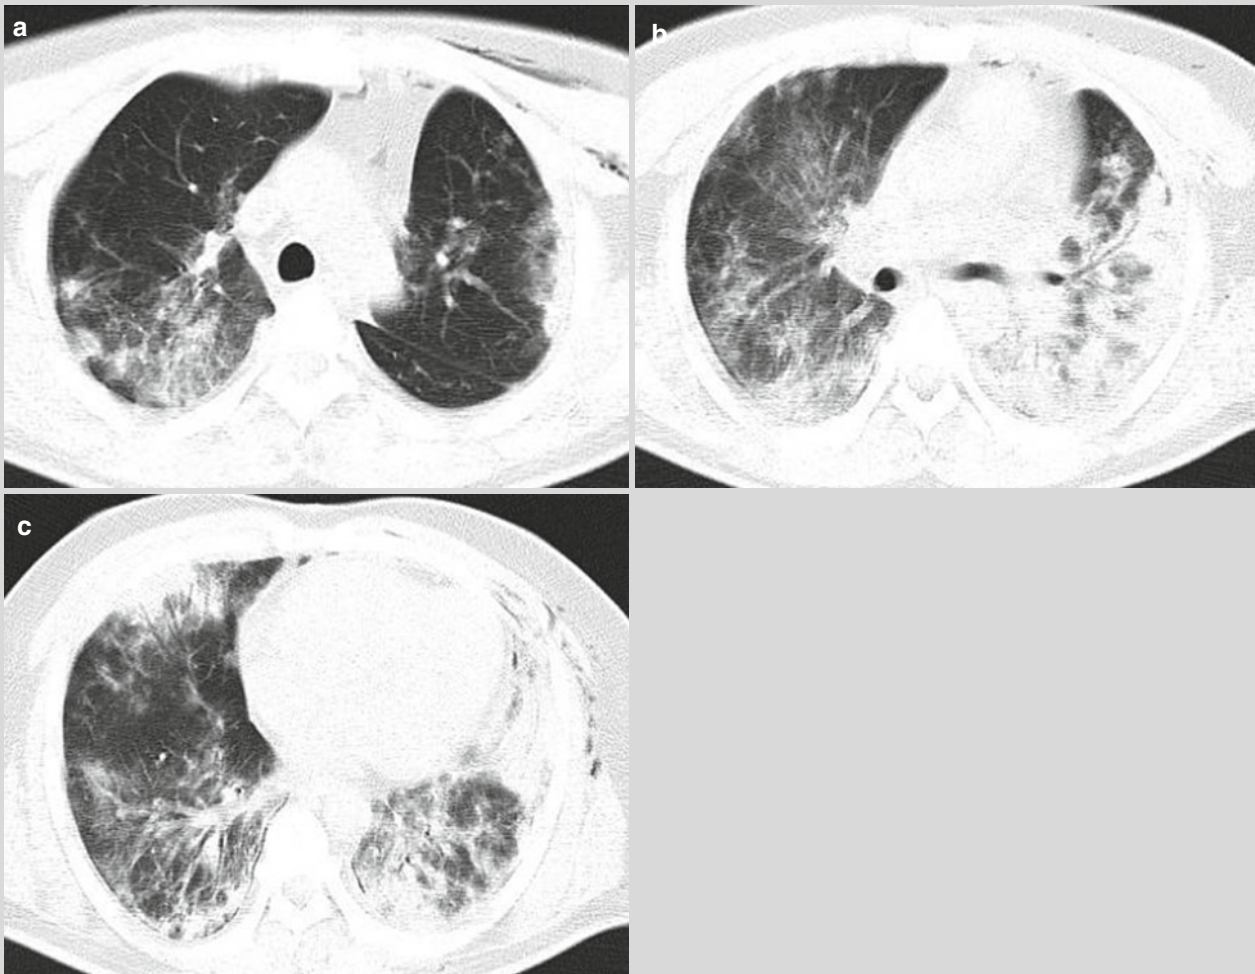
Chest CT scan showed sporadic flakes of high density opacity and ground glass opacity, predominantly in bilateral lower lung lobes; consolidation of partial lung tissues in the left lower lung lobe; beads like air density opacity in the left thoracic wall (a–c)
